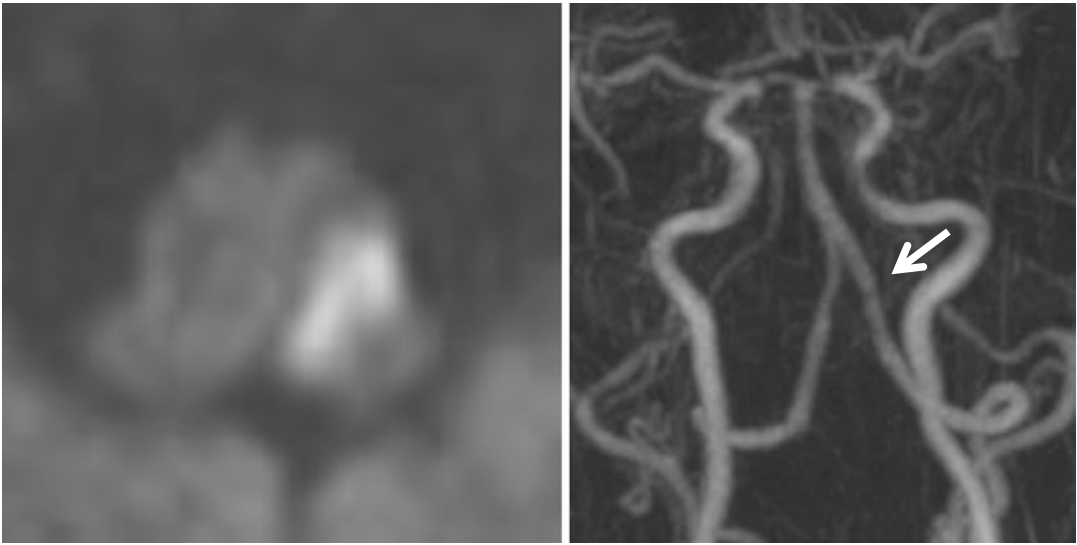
Diffusion-weighted MRI showed an infarction in the left rostral medulla. MRA showed focal, atherosclerotic narrowing (arrow) that probably occluded a perforator
